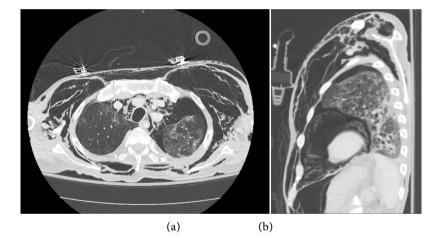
Computerized tomography (CT) imaging of the thorax and neck showing a large pneumomediastinum with concurrent pneumothorax (a) coronal view, (b) sagittal view.
